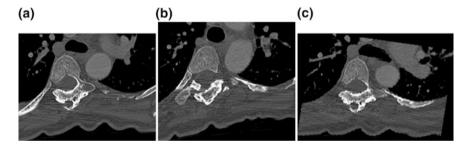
An axial cross-section of a 3D CT image of a scoliotic spine, obtained by a orthogonal MPR, b oblique MPR and c orthogonal CPR
